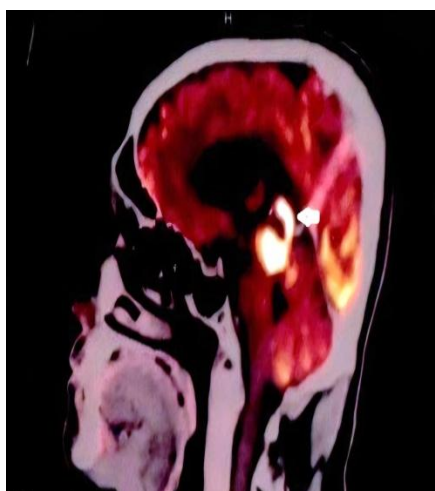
PET-CT brain's sagittal section reveals intensely FDG-avid, heterogeneously enhancing mass in the pineal region extending posteriorly to involve the splenium of the corpus callosum, measuring 30 × 29 × 31 mm (white arrow).
